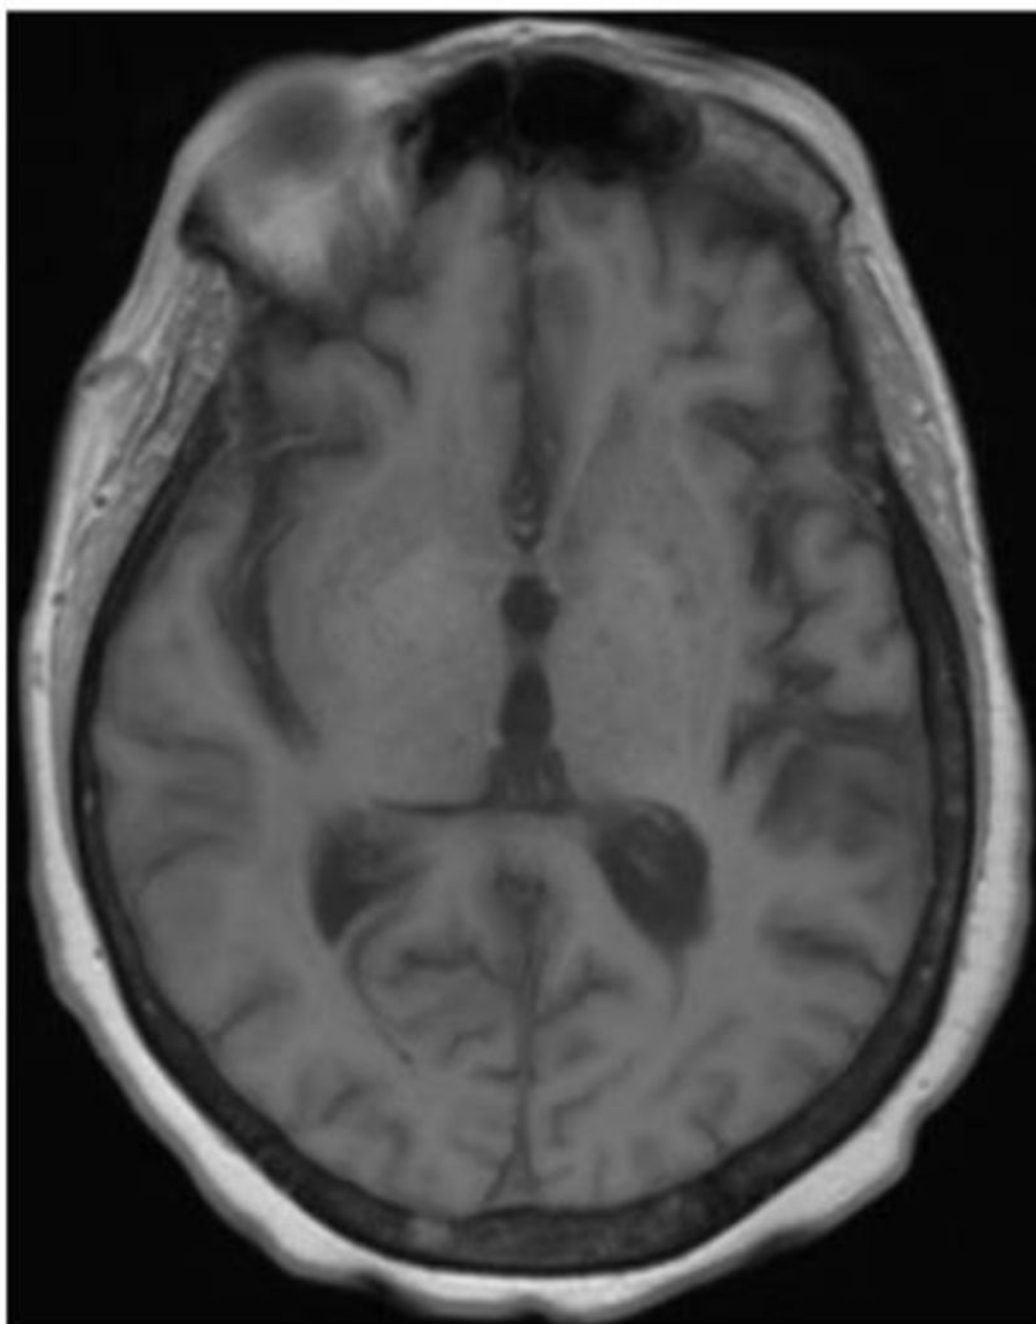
Index kidney recipient MRI brain with and without contrast three months post-transplantation
